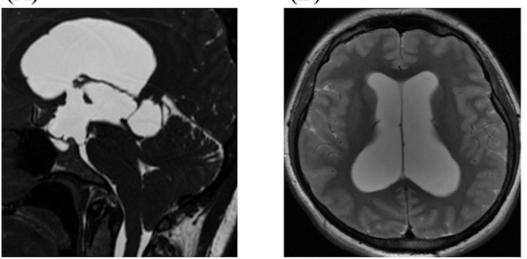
A 28-year-old female complained of chronic and progressively worsening headache after delivery of her first child. MRI (A; coronal section and B; sagittal section on T1WI) revealed an arachnoid cyst located in the quadrigeminal cistern, and cerebellar tonsillar descent with marked ventricular dilatation. Endoscopic third ventriculostomy was performed successfully and resulted in complete relief from her headaches.
